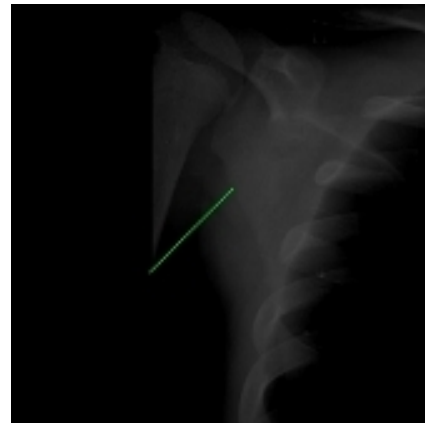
Chest plain radiograph
